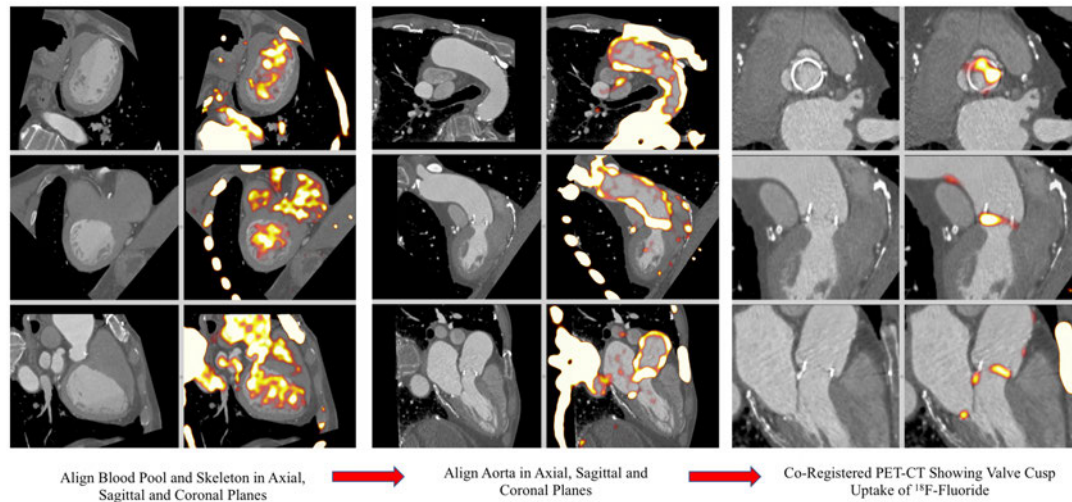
Careful alignment of PET tracer uptake in the cardiac blood pool with contrast-enhanced CT images (already re-orientated into the short axis of the aortic valve) was performed in 3 planes (left). This was possible because of high ^{18}F -fluoride activity in blood pool compared to the myocardium. Subsequently PET tracer uptake in the ascending aorta and aortic arch (centre) was aligned with the CT and final refinement of co-registration was performed according to landmarks around the aortic valve such as the coronary arteries and mitral valve annulus.
